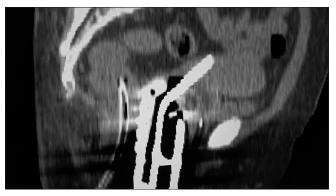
Computed tomography image of an intracavitary application showing anteversion of the uterus and posterior wall insertion of the central tandem
